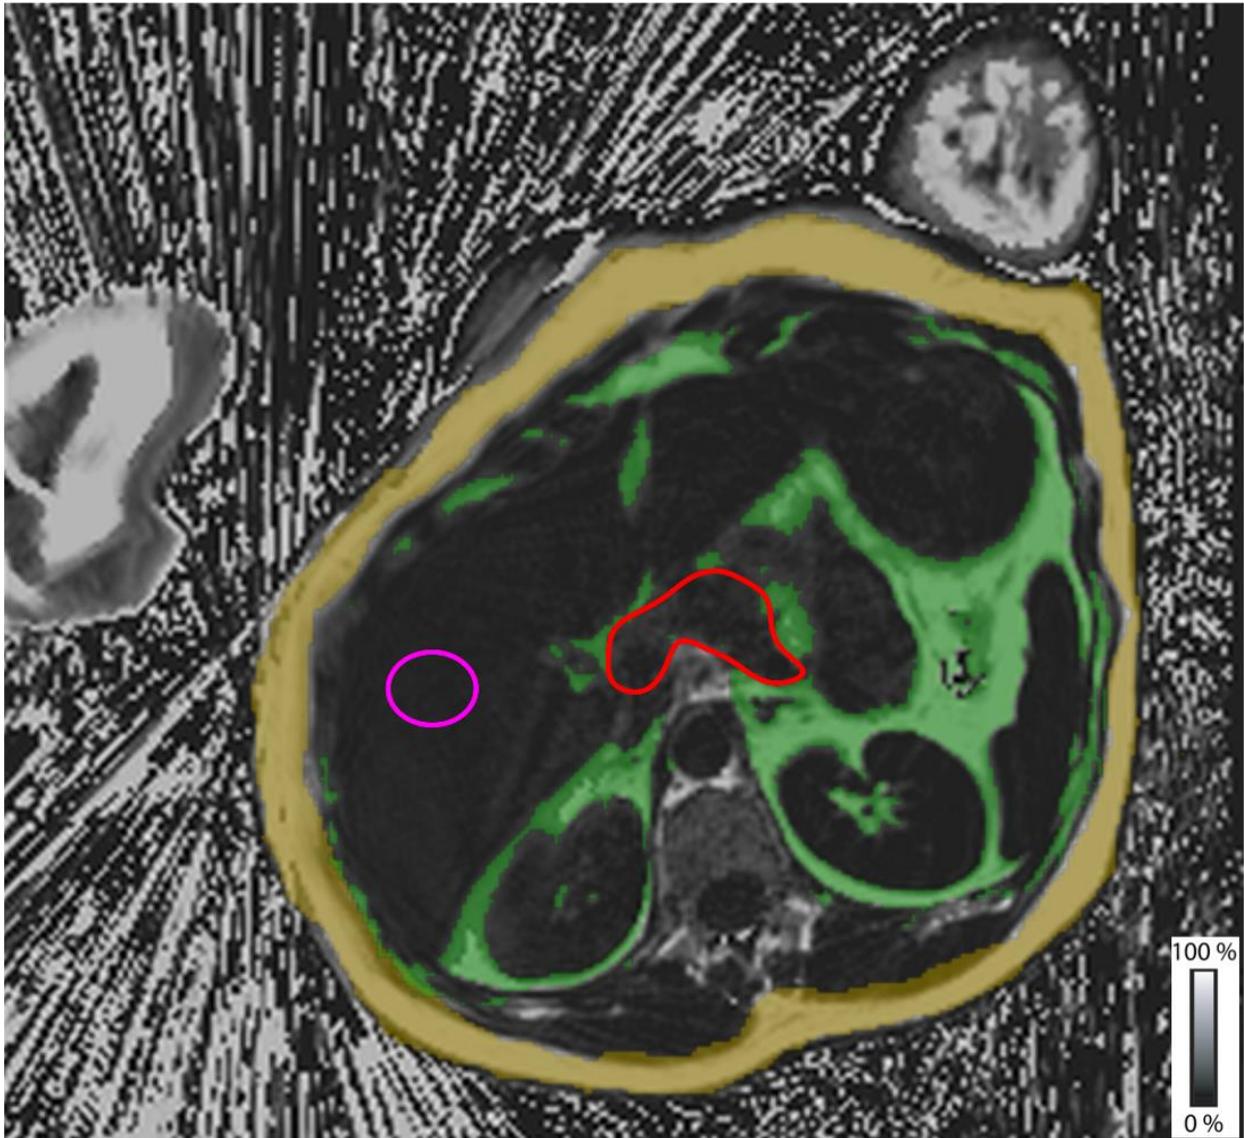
Maternal body composition measurements on a proton-density fat fraction (PDFFF) map from free-breathing MRI. As shown by the grayscale bar for PDFFF values (0-100%), white pixels have high fat content and dark pixels have low fat content. The yellow annotation represents subcutaneous adipose tissue. The green region represents visceral adipose tissue. The magenta 5-cm² region of interest was used to measure maternal liver PDFFF. The red contour outlines the maternal pancreas.
